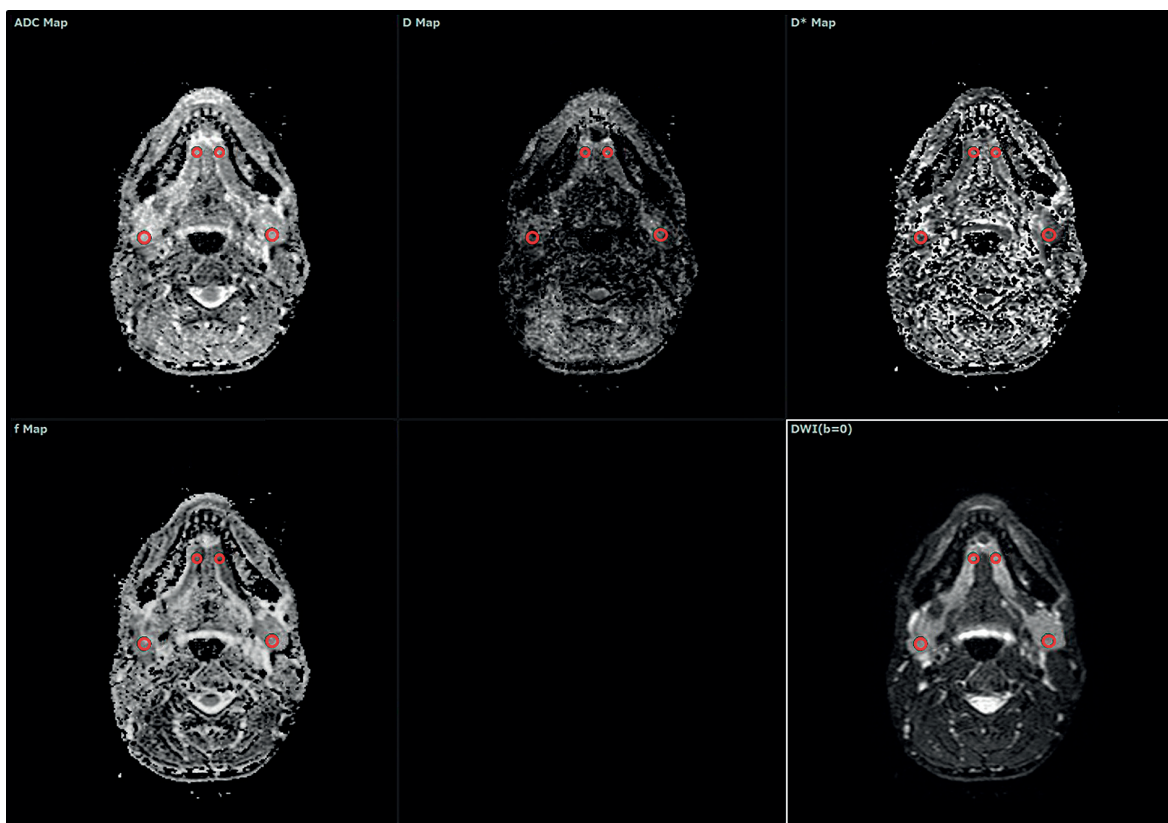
Regions of interest (ROIs) in an apparent diffusion coefficient map, D map, D* map, f map, and diffusion-weighted imaging (DWI) at a b -value of 0 s/mm^2 in the bilateral submandibular and sublingual glands. The ROIs in the bilateral submandibular and sublingual glands were set similarly to those in the bilateral parotid glands. The sizes of the ROIs are 39.5 and 23.4 mm^2 , respectively
